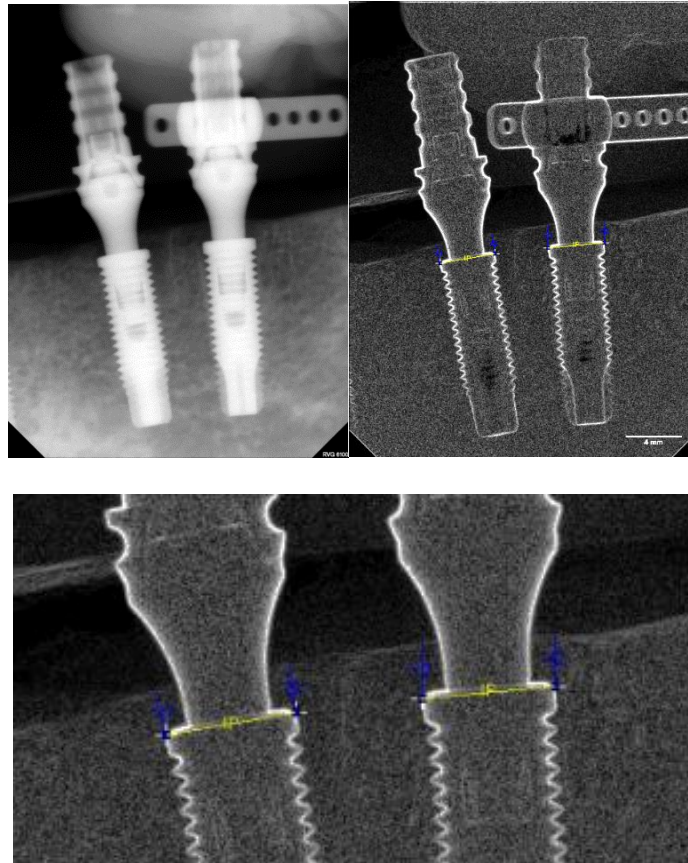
An Example of Periapical radiograph measurements
